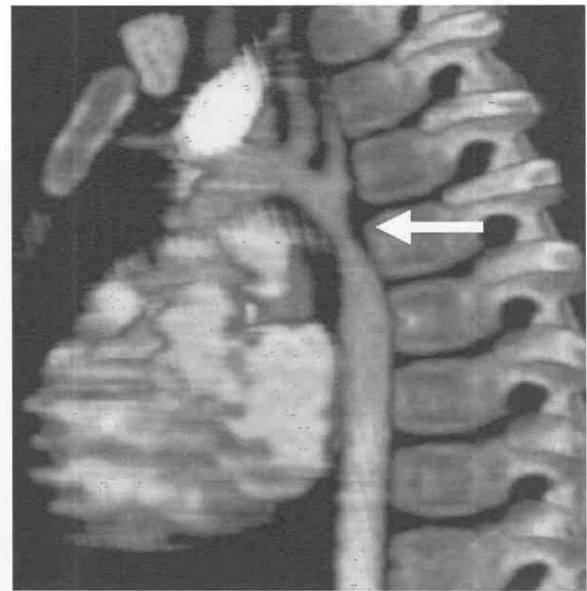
Sagittal oblique volume-rendered multislice CT scan of postductal coarctation (arrow).
